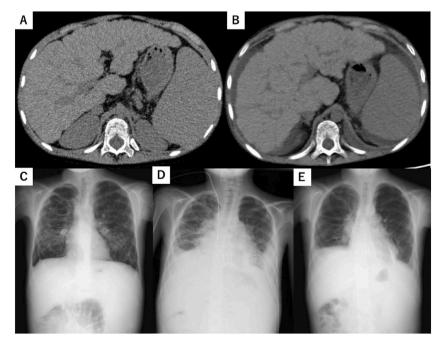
Liver cirrhosis before and after lung transplantation. (A) Preoperative abdominal CT image showing cirrhosis and splenomegaly and (B) abdominal CT image on POD16 showing ascites. Compared with preoperatively (C), an abdominal radiograph (D) on POD 18 showed an increase in ascites. The ascites improved after starting diuretics.
